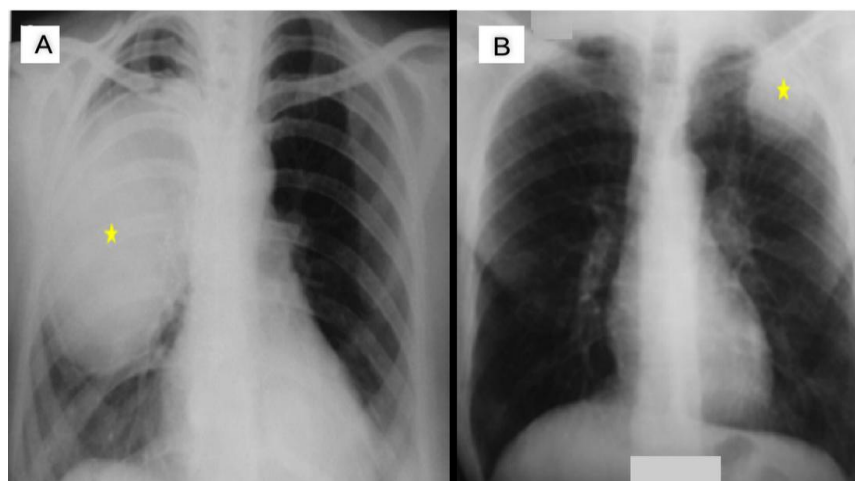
Chest radiographs of uncomplicated pulmonary hydatid cysts. (A) Right (~17 cm) and (B) left (~3 cm) homogeneous well-circumscribed masses (yellow star), consistent with uncomplicated PHCs. PHC, *Pulmonary Hydatid Cys*.
